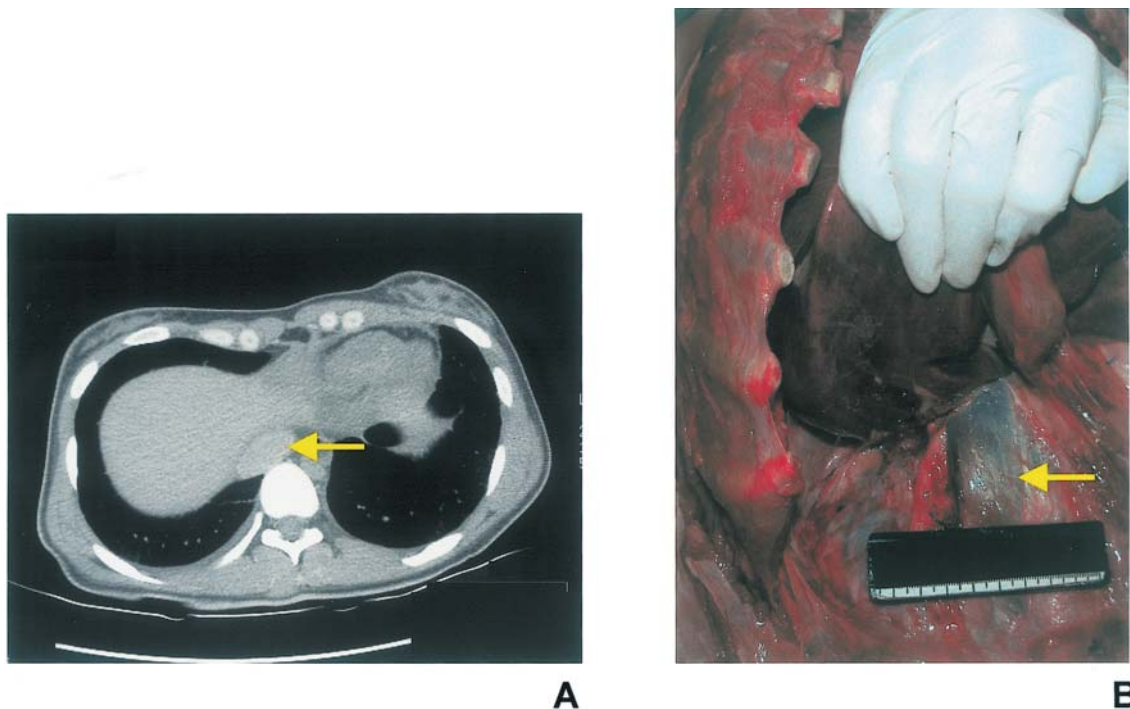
Death by drowning (Case 34): (a) axial CT image showing distension of the inferior vena cava (arrow) and engorgement of the systemic veins following right ventricular failure; (b) corresponding distension of the inferior vena cava at autopsy (arrow).
